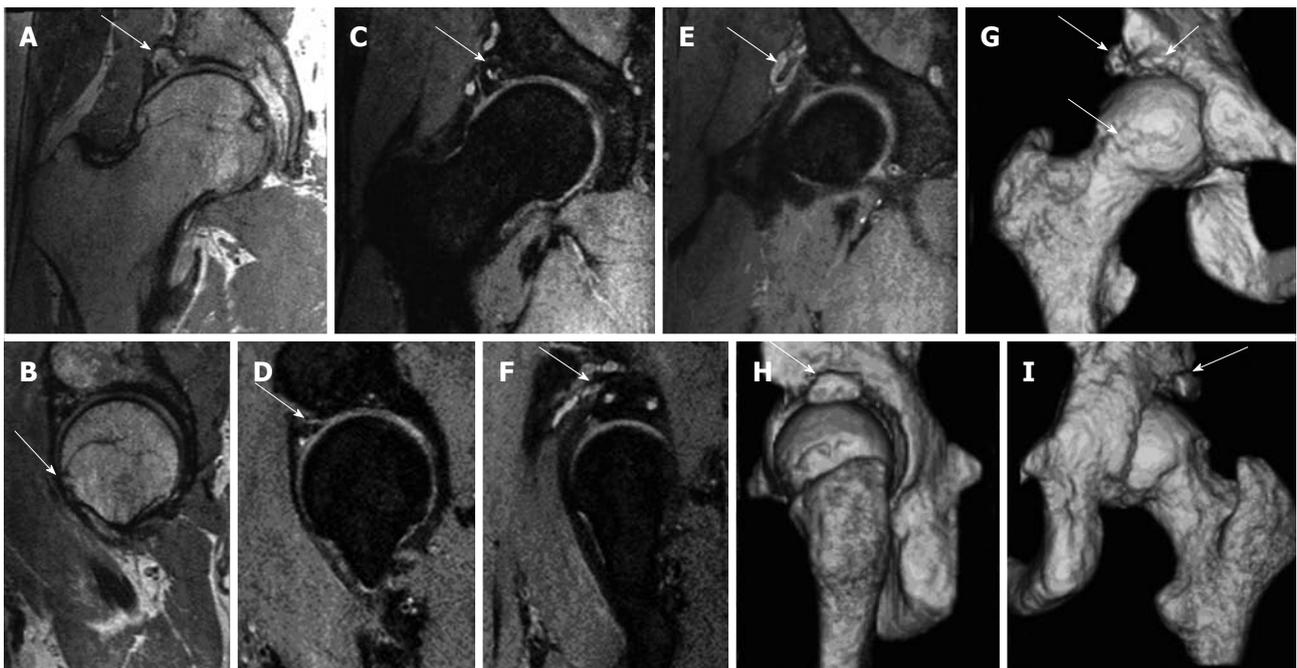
3D magnetic resonance imaging of the right hip. Multiplanar isotropic reconstructions from 3D fast spin echo proton density weighted (PDW) (A, B) and fat suppressed PDW (C-F) show the acetabular rim fracture (arrows in A, C, F) with pseudoarthrosis and cystic changes; paralabral cyst wrapping around the rectus femoris tendon (arrows in E, F) and CAM deformity (arrow in B). 3D surface rendered bone reconstructions show the bony changes akin to the computed tomography (CT) images with a CAM deformity and bone fragments (arrows in G) and the rim fracture (arrows in H, I), as with 3D CT.
